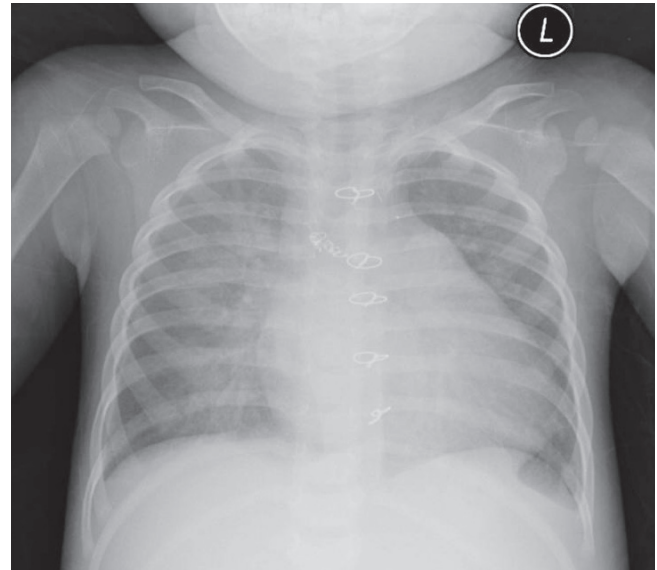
Chest radiograph shows increased ground glass opacity in the whole lung field, which represents interstitial pneumonia.
